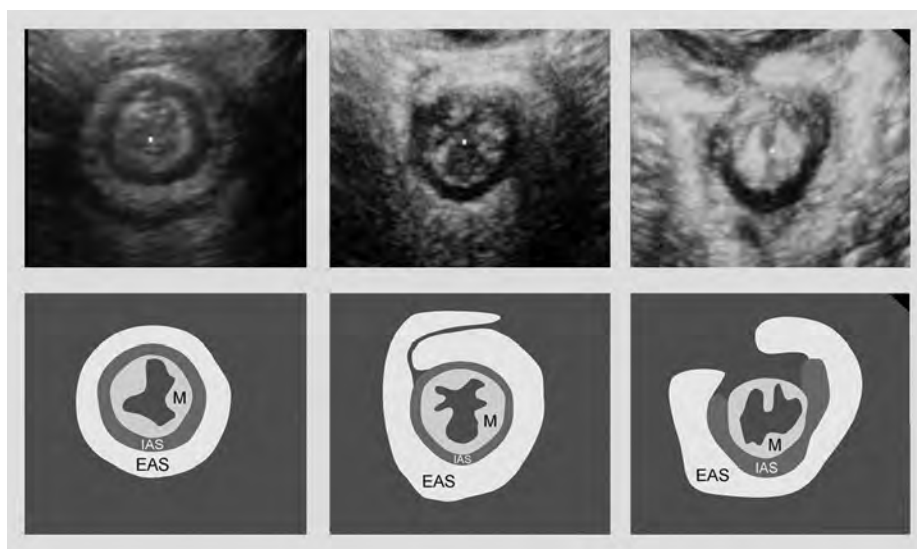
Transperineal ultrasound of the anal sphincters
